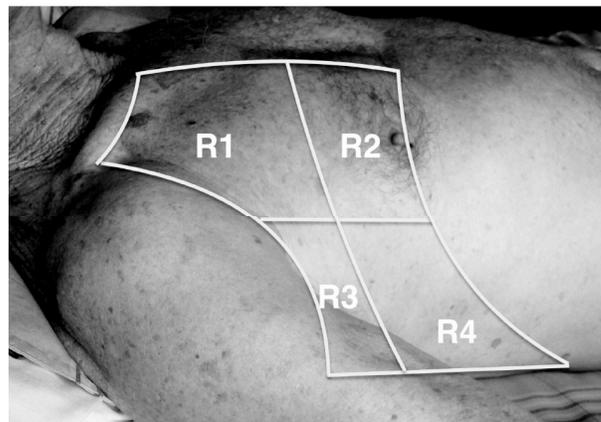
Eight zone lung ultrasound examination: Each anterior chest wall is separated into two regions; anterior and lateral, by using parasternal line, anterior axillary line and posterior axillary line as anatomical landmarks and then each of those regions are subdivided into upper and basal parts (R1-R4).
